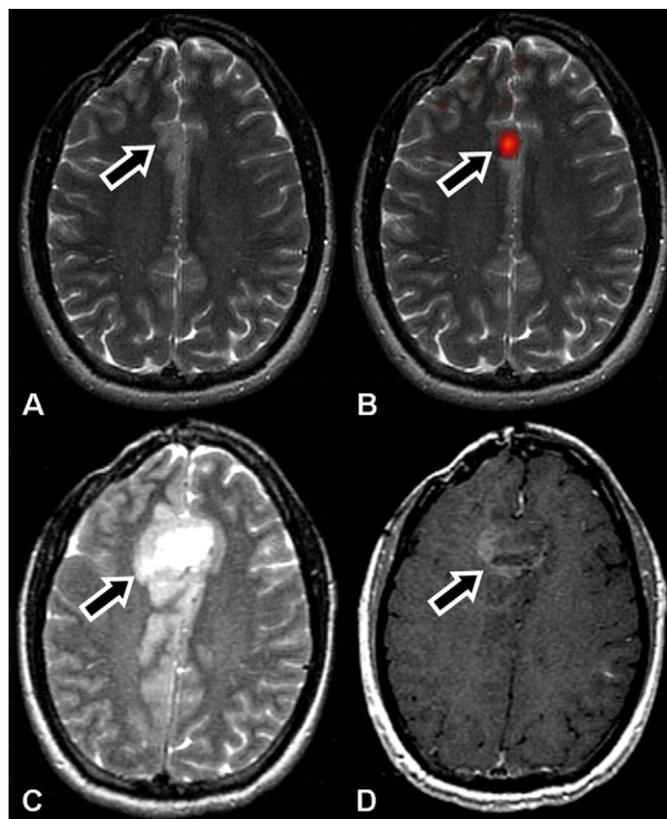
In this patient, elevated  $^{18}\text{F}$ -FDOPA activity is seen at the margins of the resection cavity corresponding to a region of abnormal contrast enhancement (not shown). More superiorly, a non-enhancing area subtly expands the cortex in the parasagittal frontal lobe as shown on axial T2W MRI (A, arrow) also exhibits increased  $^{18}\text{F}$ -FDOPA activity (B, arrow). There was significant interval tumor growth into this previously PET-delineated tumor region on 7-month follow-up MRI scan (T2W MRI (C, arrow) and contrasted-enhanced T1W MRI (D, arrow)).
